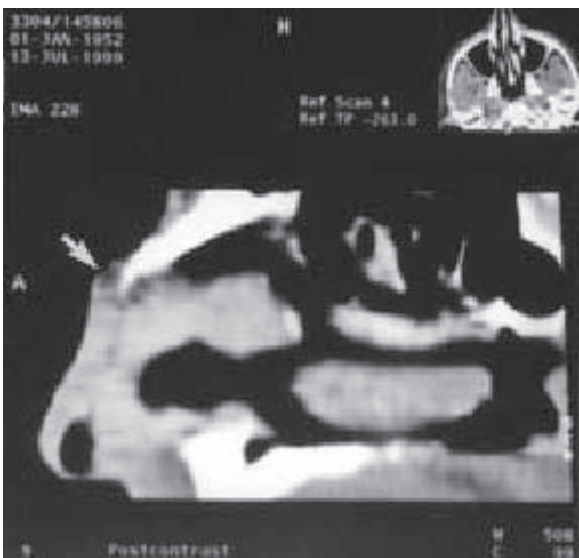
Sagittal reconstruction of the axial CT scan shows the nasal dorsum cyst (arrow) without an intracranial extension.
